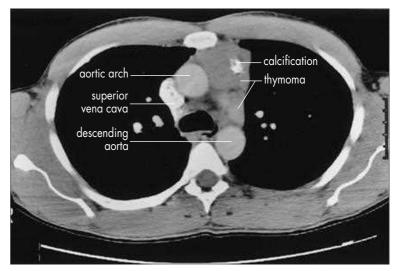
Computed Tomography of the Chest With Contrast Enhancement. A large, multilobulated thymoma in a 32-year-old man with ocular myasthenia gravis. The mass is in proximity to the aortic arch and the ascending aorta. A focal calcification is present anteriorly. The patient's ptosis and diplopia remitted after removal of the thymoma.
